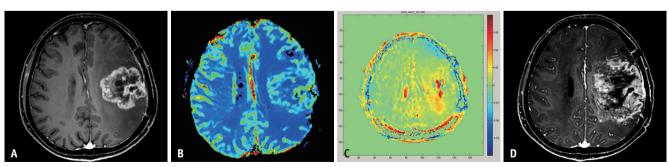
A 65-year-old female presenting with an enhancing mass in the left frontoparietal lobe on MRI after postoperative concurrent chemoradiotherapy for glioblastoma (A). The mass demonstrates a mild increase in relative cerebral blood volume (B) and an increase in the amide proton transfer signal (C). The follow-up MRI shows increased enhancing mass (D), suggesting recurrent glioblastoma.
